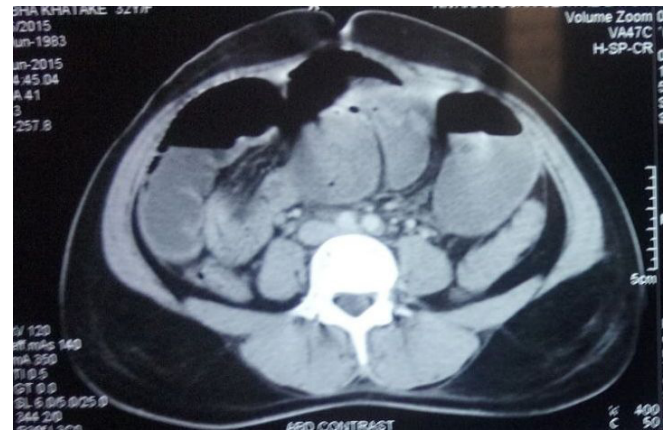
CT showing clumping of dilated ileal loops.
